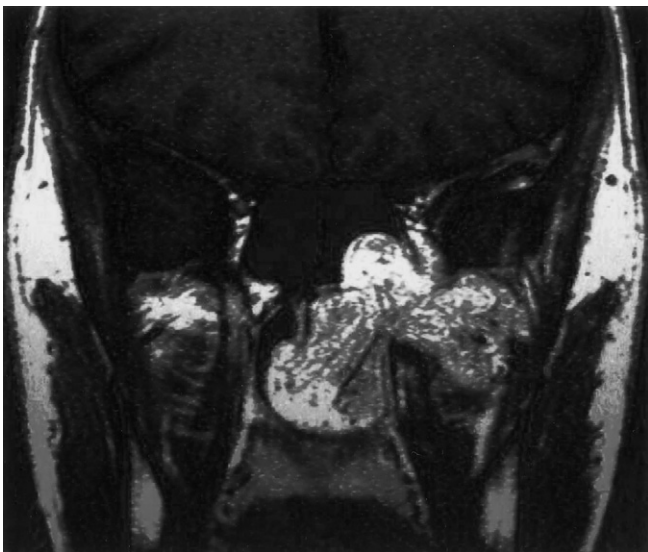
MRI scan of a 16-year-old boy with a left-sided juvenile angiofibroma. The tumor arose in the pterygomaxillary region and has extended into the nasopharynx and infratemporal fossa. (Courtesy Dr. J. Netterville.)
